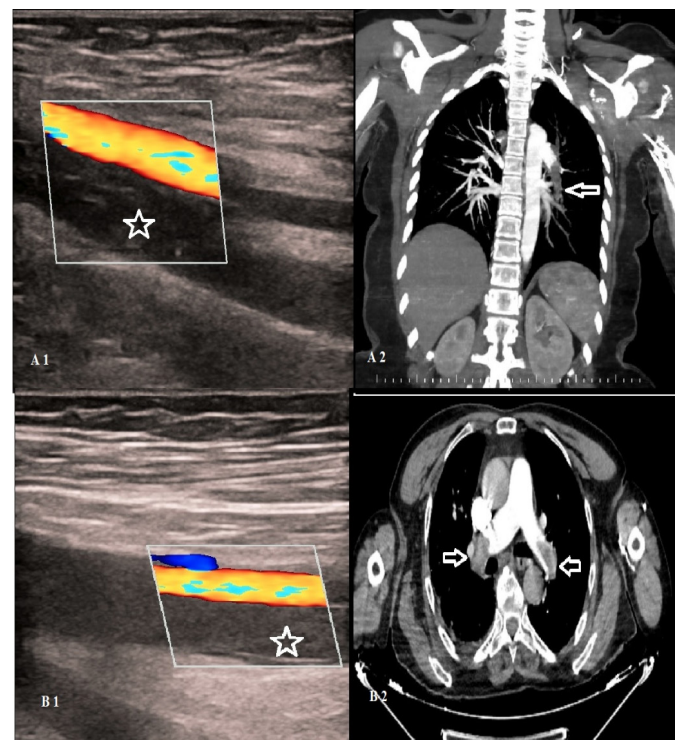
Case examples. A 32-year-old female patient with no known risk factors and a Tyg index of 8.95 is shown to have acute DVT in the right superficial femoral vein on USG Doppler examination (A1) and embolism findings in the left pulmonary artery lumen on CTPA images of the same patient (A2). A 72-year-old male patient with a TyG index of 9.40, known to have diabetes, hypertension and smoking history, shows a DVT in the right superficial femoral vein that does not allow flow on USG Doppler examination (B1) and bilateral pulmonary artery embolism findings on CTPA images (B2).
